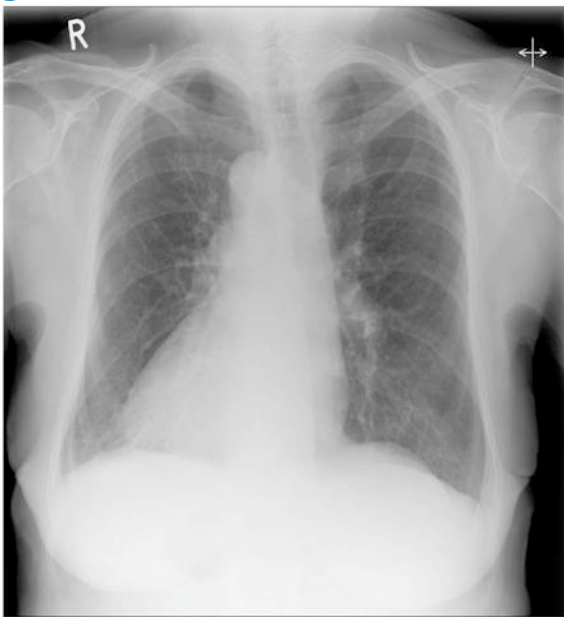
Dextrocardia is demonstrated on this frontal chest radiograph.
